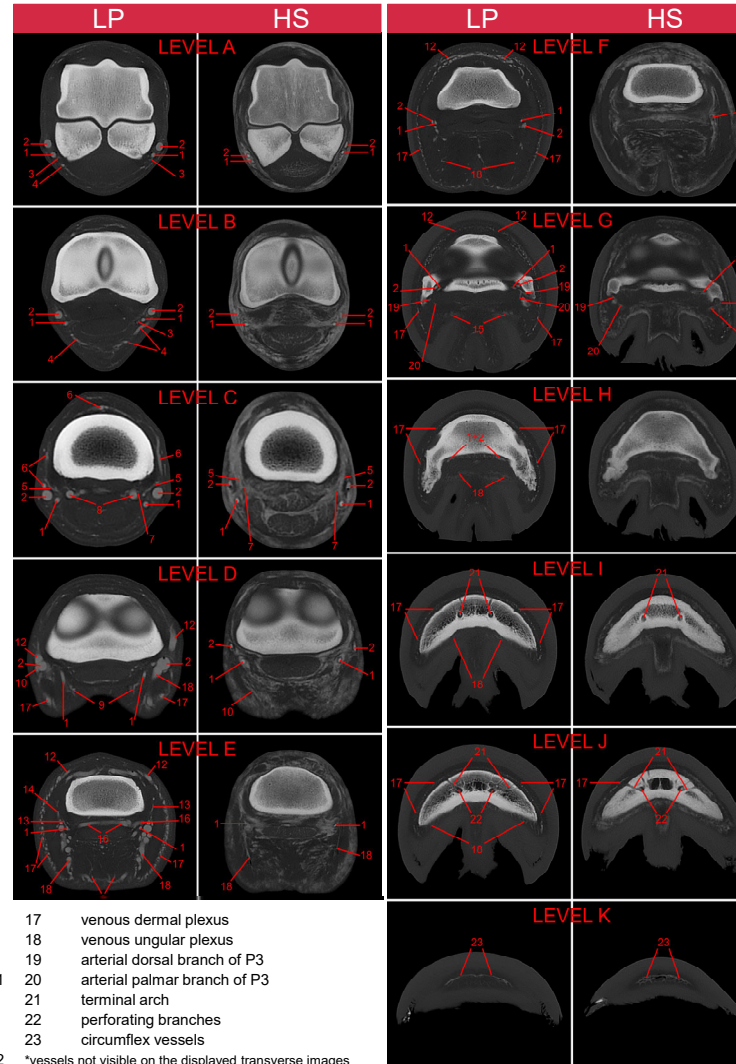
(right): Comparison of paired transverse images (levels A-K) of post-mortem CT angiography performed with either lipophilic (LP; left images) or hydrosoluble (HS; right images) contrast media. The following vessels were evaluated:
